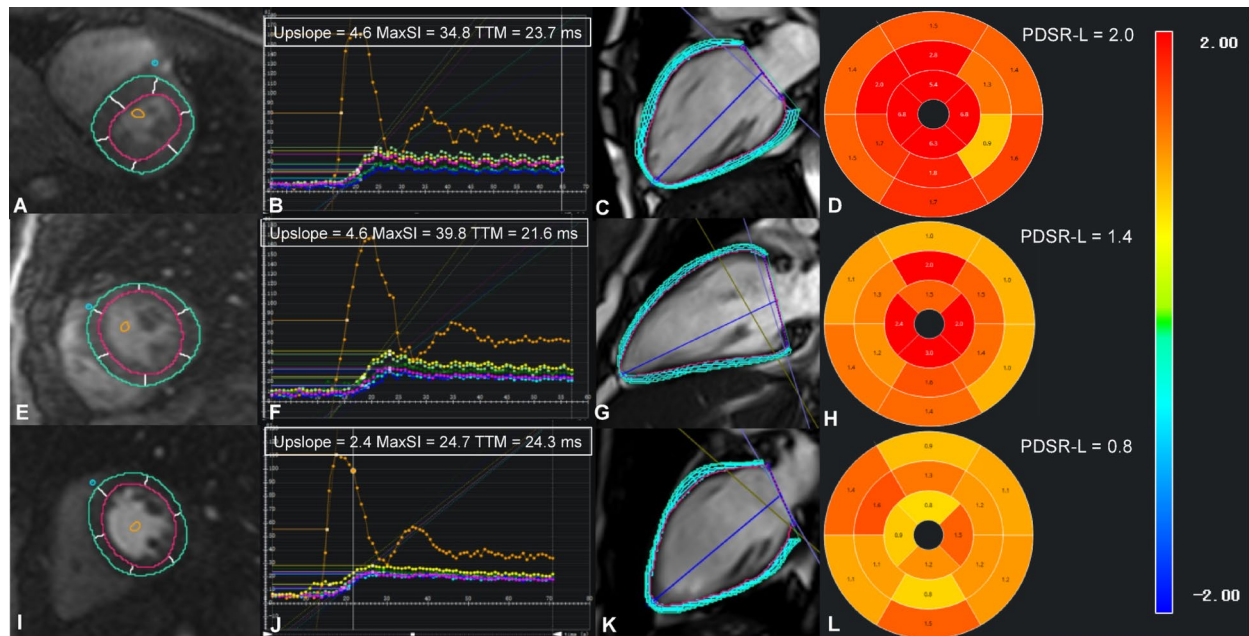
Representative cases showed myocardial perfusion function and longitudinal peak diastolic strain rate (PDSR-L) in a control (top row), a patient with HbA1c < 7.0% (middle row), and a patient with HbA1c ≥ 7.0% (bottom row). First-pass myocardial perfusion MR images (A, E, and I) and signal intensity-time curves (B, F, and J) were obtained from the left mid-ventricular slices. PDSR-L was analyzed using Bull's-eye plots (D, H, and L) derived from long-axis cine images (C, G, and K). Max SI, maximum signal intensity; TTM, time to maximum signal intensity
